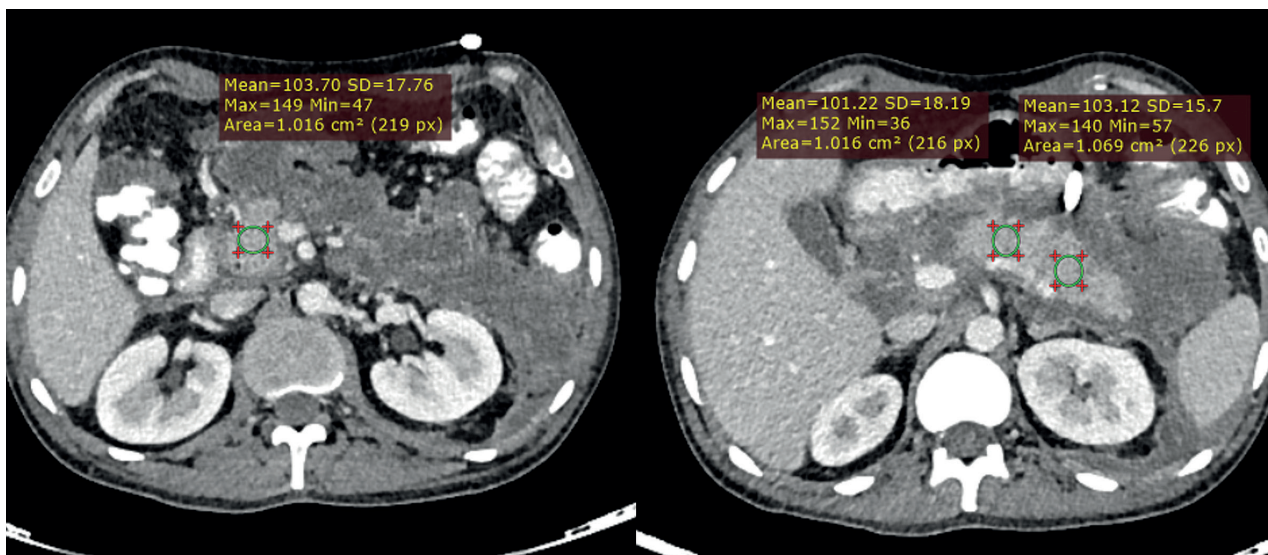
Axial CT images in a 36-year-old patient with alcohol induced acute pancreatitis with isolated EPN. The pancreatic attenuation values were greater than 100 HU in the head, body and tail (absolute values given by cursors).
